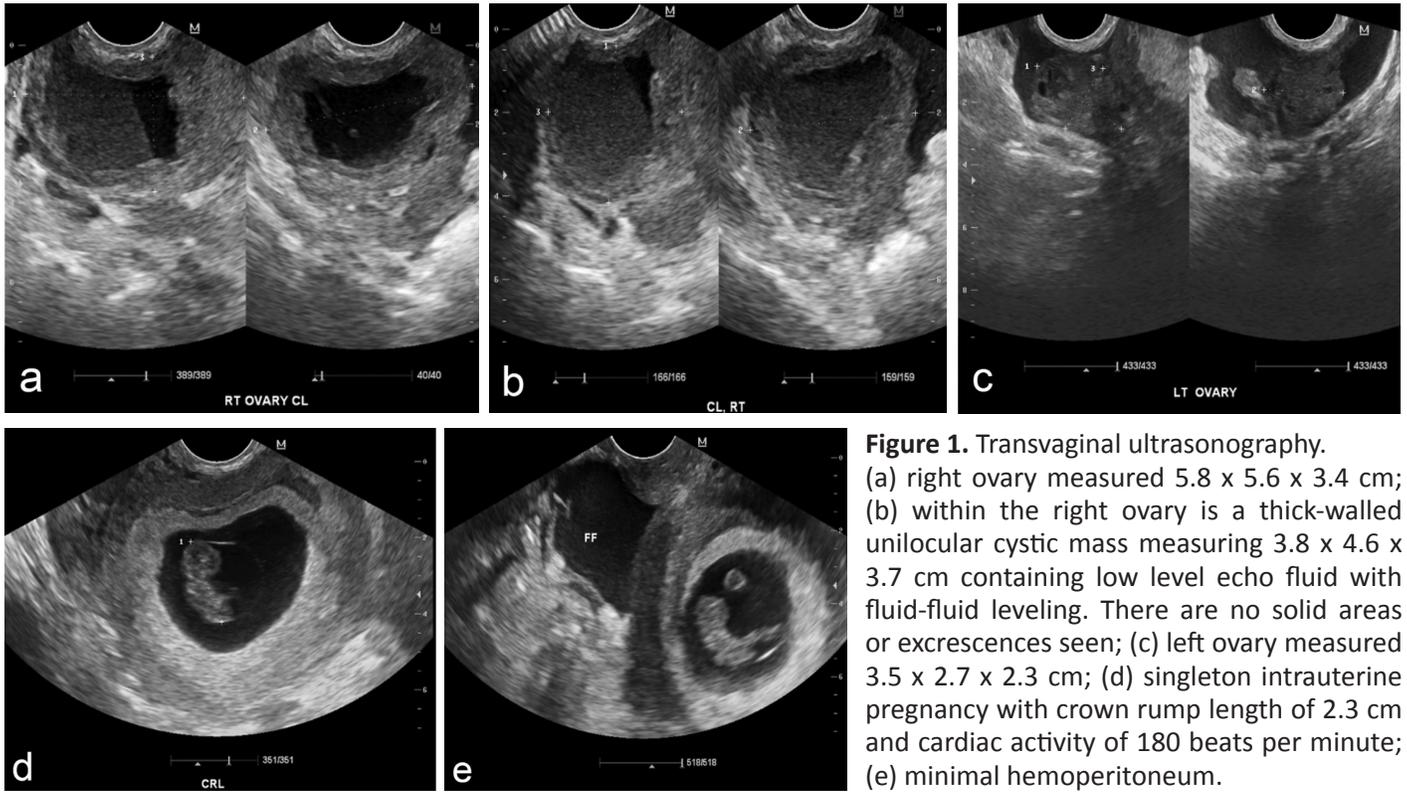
Transvaginal ultrasonography. (a) right ovary measured 5.8 x 5.6 x 3.4 cm; (b) within the right ovary is a thick-walled unilocular cystic mass measuring 3.8 x 4.6 x 3.7 cm containing low level echo fluid with fluid-fluid leveling. There are no solid areas or excrescences seen; (c) left ovary measured 3.5 x 2.7 x 2.3 cm; (d) singleton intrauterine pregnancy with crown rump length of 2.3 cm and cardiac activity of 180 beats per minute; (e) minimal hemoperitoneum.
